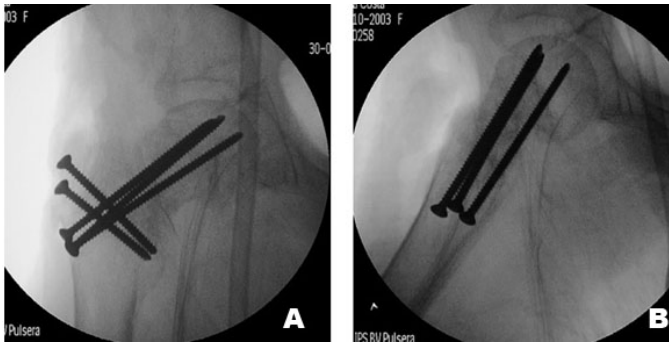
Final intra-operative X-rays showing the optimal reduction achieved in the second surgical procedure (anteroposterior (A) and lateral (B) views).
